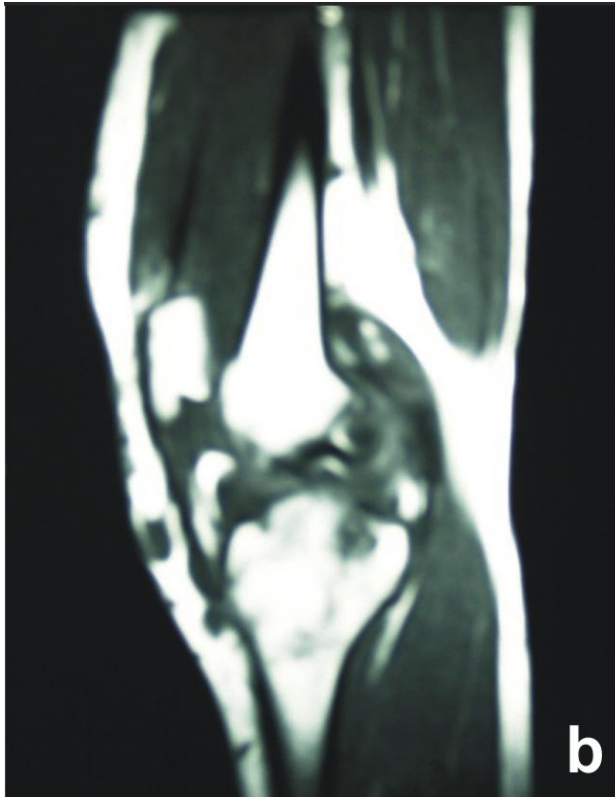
(b) Sagittal T.W MRI showing hypertrophic synovium
